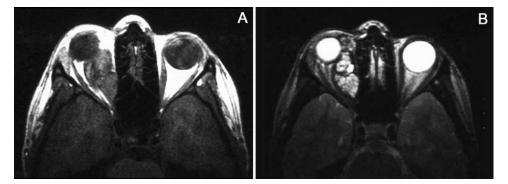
(A) Coronal T1weighted image of a relatively homogeneous mass in right orbit, isointense to the ocular muscles. (B) This T2-weighted image shows a multicompartment cystic mass with high signal indicating fluid. The lesion was a lymphangioma.
